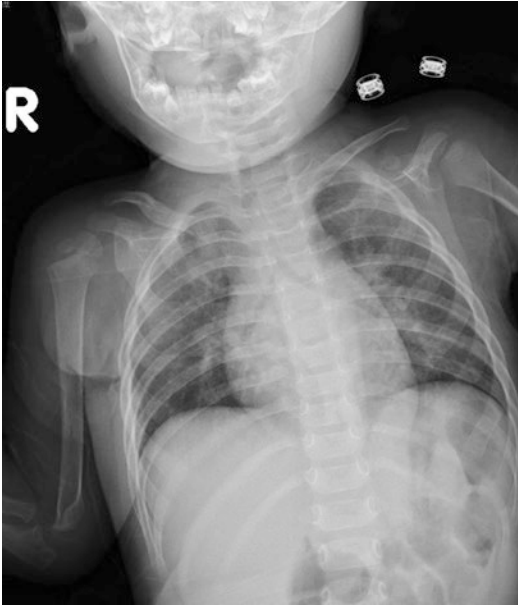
Chest X-ray of case 1 with respiratory syncytial virus infection. The chest film reveals increased infiltrations in bilateral lung fields
